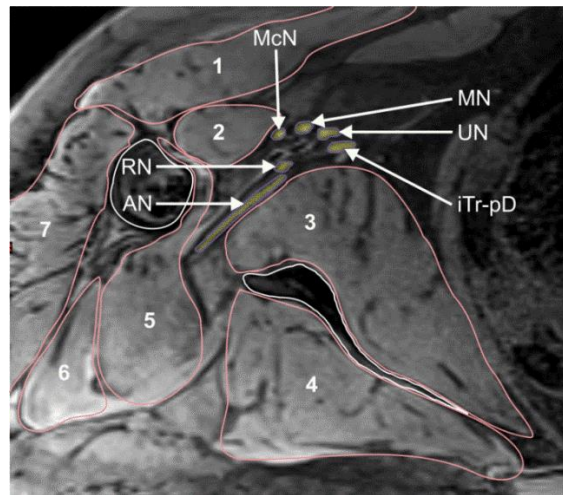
MRI axial slice of the most lateral brachial plexus region, on the level of axillary nerve origin. The brachial plexus is depicted in purple (AN, axillary nerve; RN, radial nerve; McN, musculocutaneous nerve; MN, median nerve; UN, ulnar nerve; iTr-pD, inferior Trunk-posterior Division), muscles are pink (1, major pectoral muscle; 2, coracobrachial muscle; 3, subscapular muscle; 4, infraspinatus muscle; 5, teres major muscle; 6, triceps muscle; 7, deltoid muscle)
